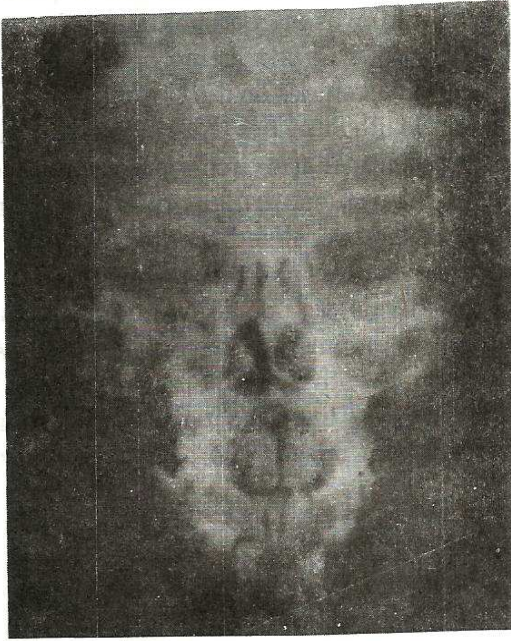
Radiograph of maxillary sinuses showing opacity consistent with sinusitis.
